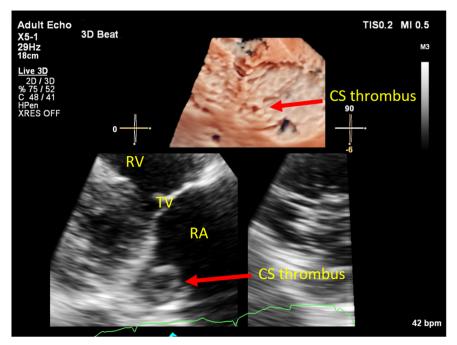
Three-dimensional TTE, parasternal long-axis right ventricular inflow view, diastolic phase with 3D volume-rendered (tissueenhanced) display (*top*) and 2D orthogonal long-axis (*bottom left*) and short-axis (*bottom right*) displays, demonstrates a large thrombus in the CS (*arrow*). *TV*, Tricuspid valve.
